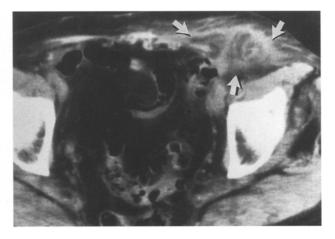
CT in a patient with left lower quadrant pain shows ill-defined inflammatory mass in the region of the left groin (*arrows*). This was caused by incarcerated and infarcted appendices epiploicae from the serosal surface of the sigmoid colon.
